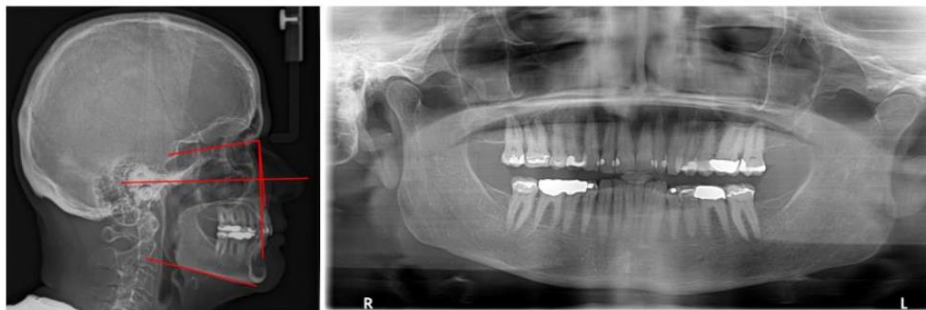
series b: Cephalometric radiograph reveals a low mandibular plane angle and orthognathic jaw relationships. Panoramic radiograph reveals multiple dental restorations and missing third molars.
